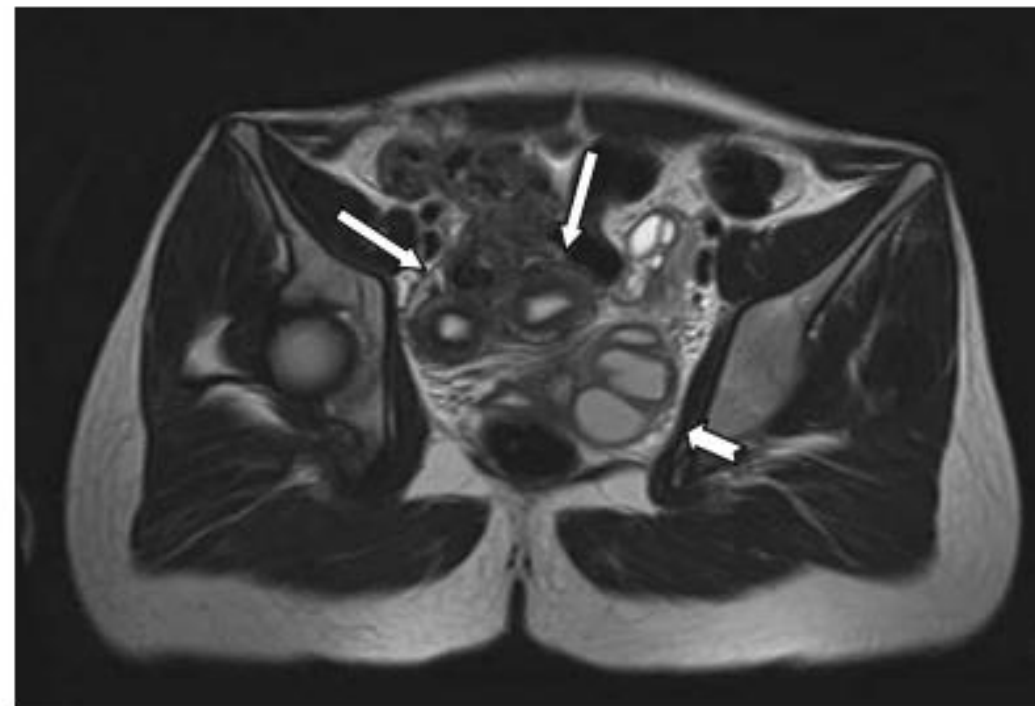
MRI scan (paracoronaral T2-weighted image) showing the tortuous saccular dilated structure in the left hemipelvis (*thick arrow*) and the two uterine cavities (*thin arrows*)
